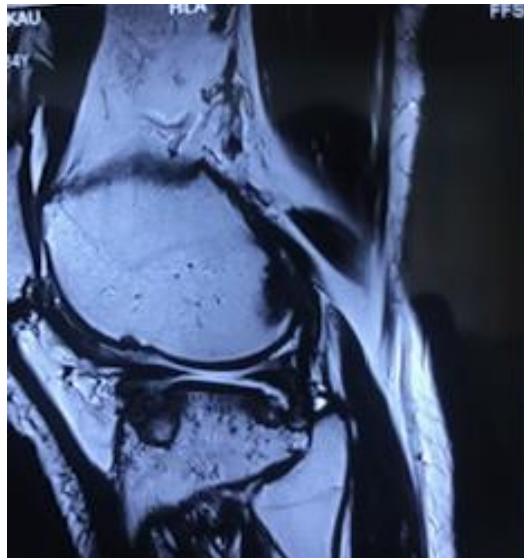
A: pre-operative MRI Scan showing extensive articular damage with extension into the subchondral bone.
